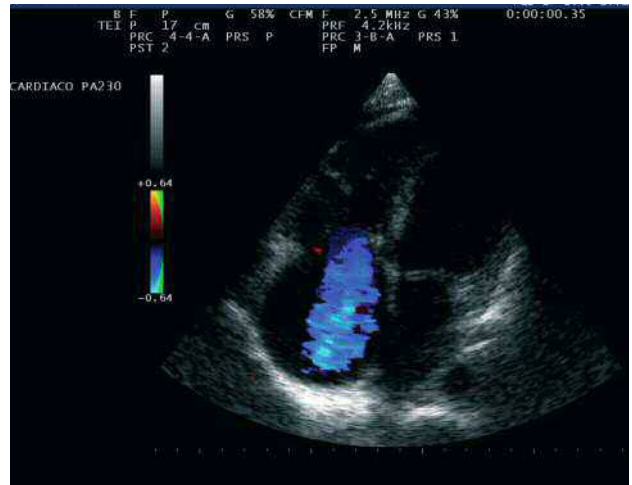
Transthoracic Doppler echocardiography. Apical four chamber view of mild atrial dilation, mild right ventricular enlargement, mild posterior pericardial effusion, and tricuspid valve with sclerosis, thickening and hypomobile leaflets with severe regurgitation.
